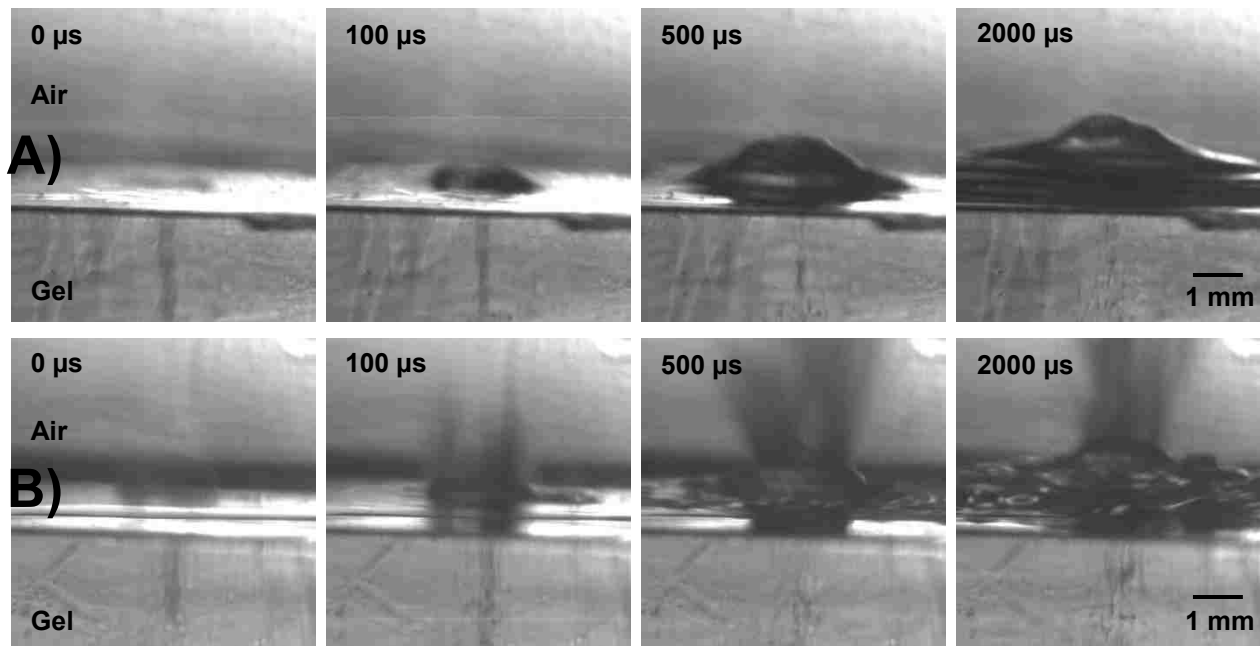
Selected frames from high speed videos of dry (A) and wetted (B) polyacrylamide gel. A) The dry polyacrylamide gel shows subsurface cavitation that is present in the first frame (labeled as 0 μs but actually 70 μs after the ultrasound wave encounters the gel-air interface). In the next frame, (100 μs) the mound has formed, though subsurface cavitation is still present. In the next two frames, subsurface bubble activity continues and the mound of gel continues to grow, but no jets are emitted from the gel surface. B) The water-wetted polyacrylamide gel also shows subsurface cavitation in the first frame (labeled as 0 μs but actually 70 μs after the ultrasound wave encounters the gel-air interface) as well as an initial spray of water from the surface. By the next frame, (100 μs) there is a slight mound forming, with jetting from the surface; subsurface cavitation is still visible. The final two frames shows still more atomization of the liquid and gel from a growing mound. Subsurface bubble activity seems to have subsided by the third frame (500 μs), though more bubbles have formed below the surface by the fourth frame (20000 μs). Both videos were taken at the maximum 24,000 W/cm^2 intensity and 10-ms HIFU exposures.
